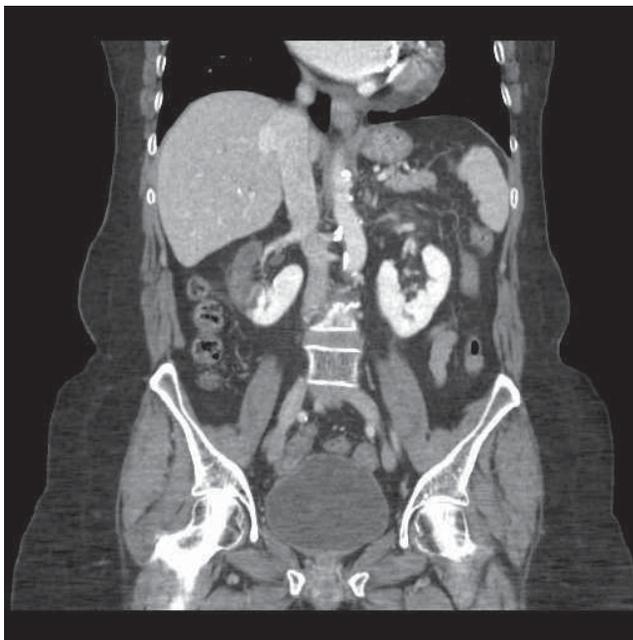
Contrast-enhanced abdominal CT (sagittal vue): several hypodense areas in the upper two thirds of the right kidney.
